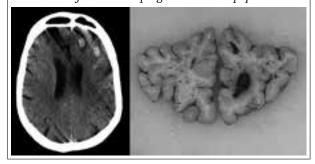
Cerebral lesions on CT scan were classified as metastates of invasive aspergillosis at autopsy
